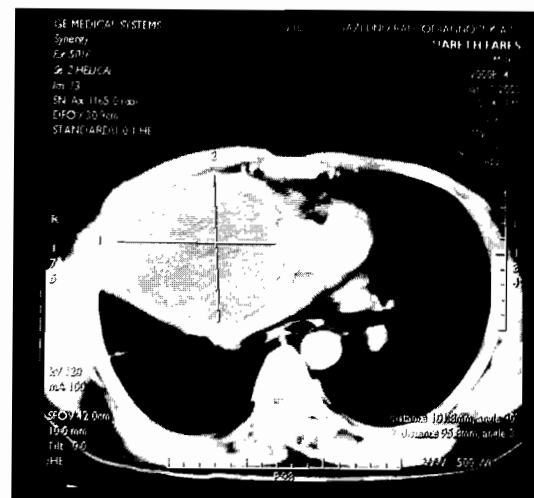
Computed tomographic image of Yolk Sac tumor.
